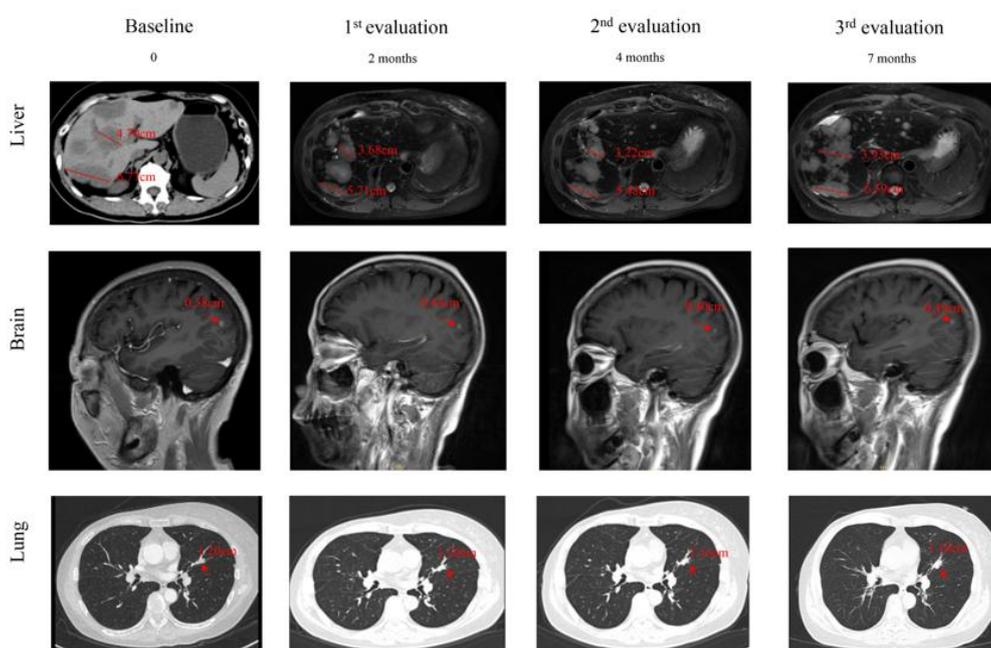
Tumor size before and during the course sacituzumab govitecan treatment. MRI scans and CT scans were performed 1.5 months before starting sacituzumab govitecan (column 1), at first evaluation (MRI scans and CT scans 2months after starting sacituzumab govitecan, column 2), at best response (MRI scans CT scans 4 months after starting sacituzumab govitecan, column 3), and at progression (MRI scans and CT scans 7 months after starting sacituzumab govitecan, column 4).
